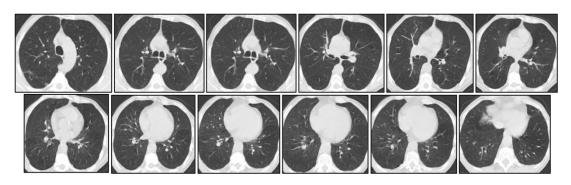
Non-COVID-19 Lung CT-Scans
